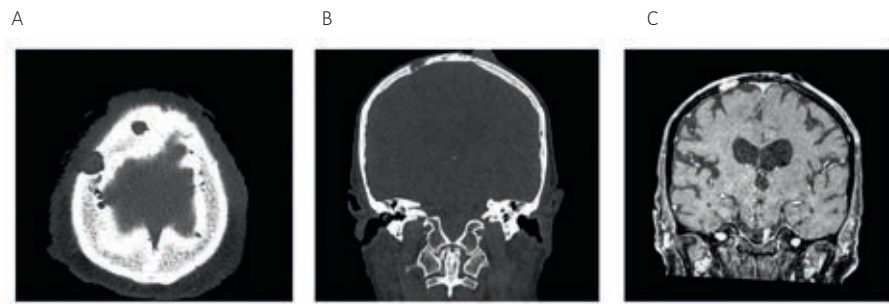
A) Axial and B) coronal slides of the computer tomography demonstrating bone invasion. C) MRI images excluded dural involvement.
